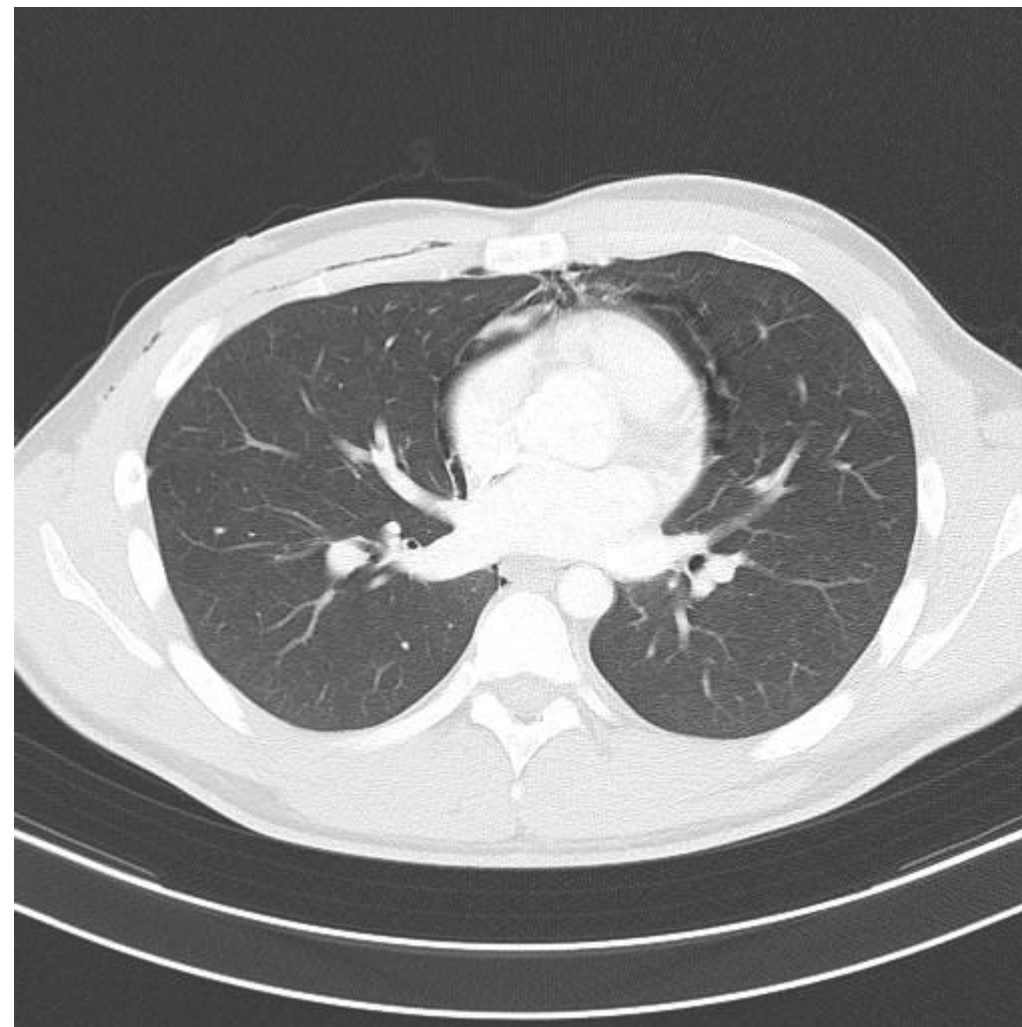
Axial CT: Pneumomediastinum with gas tracking into the base of the neck, both supraclavicular fossae, the right axilla and down the anterior chest wall [5].
